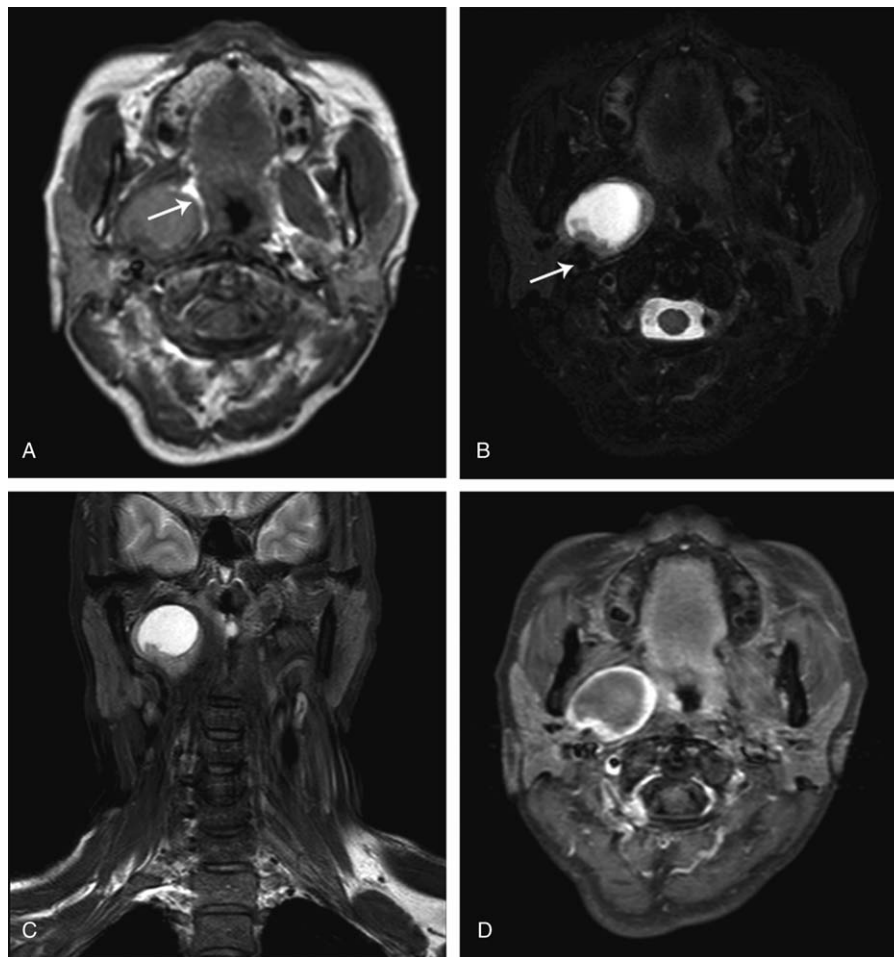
Magnetic resonance imaging (MRI) of case 1 showed a predominantly cystic mass occupying the right parapharyngeal space. The mass was well defined with a diameter of 33 mm. (A) On axial T1-weighted MRIs, the central cystic content showed a homogeneous slightly hyperintense signal versus muscle. The peripheral solid rim showed an isointense signal versus muscle. A fat cap sign was visible at the anterior and medial side of the mass (arrow). (B and C) On axial and coronal T2-weighted images, the central content showed an intensely hyperintense signal and the peripheral rim showed a slightly hyperintense signal, relative to muscle. The structure of the carotid sheath was displaced posteriorly (arrow). (D) On axial enhanced T1-weighted MRIs, the peripheral rim was intensely enhanced after administration of intravenous gadolinium.
